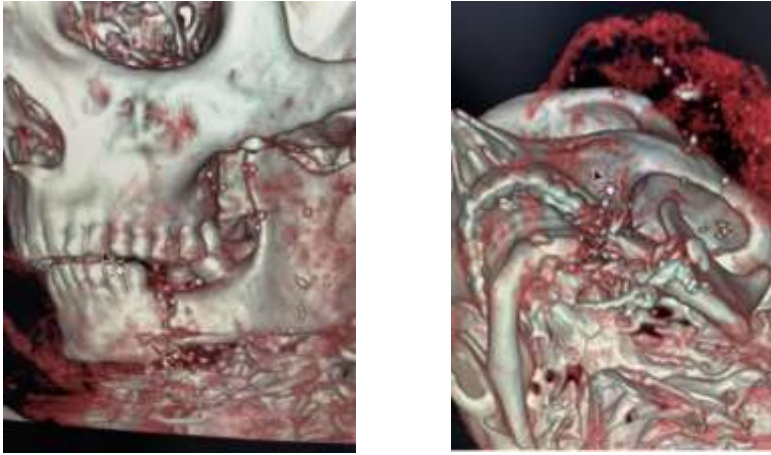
Anteroposterior view of preoperative 3-D CT scan showing comminuted fracture of mandible resulting from gunshot injuries.
